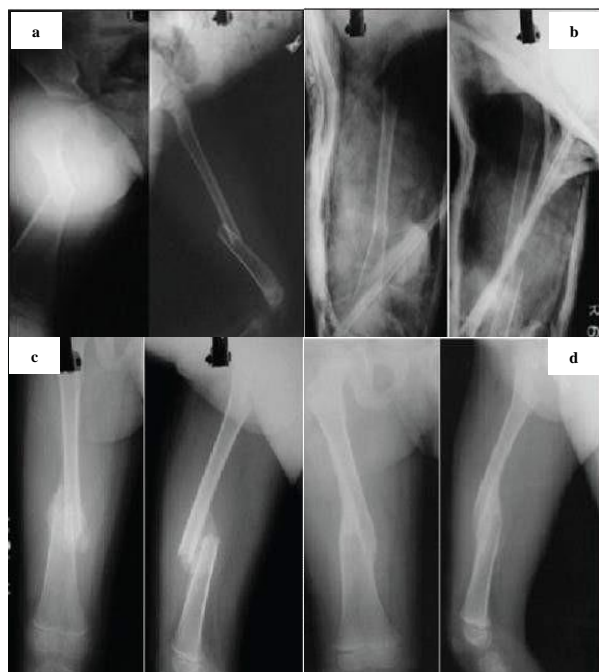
Pre-cast (a) and post-cast [immediate (b), 3 months (c), 6 months (d)] radiographic images
